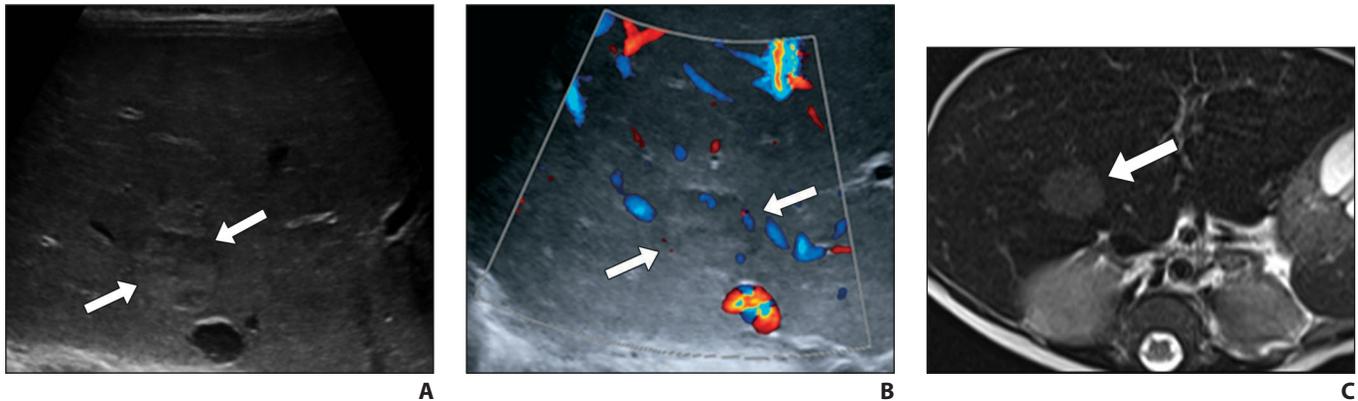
4-month old boy with trisomy 18 undergoing abdominal ultrasound to evaluate abdominal distention.
